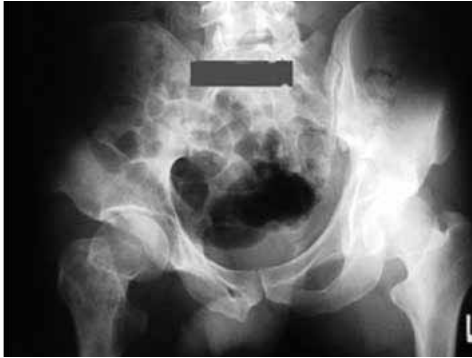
Plain X-Ray, single bone metastasis in right femur.
